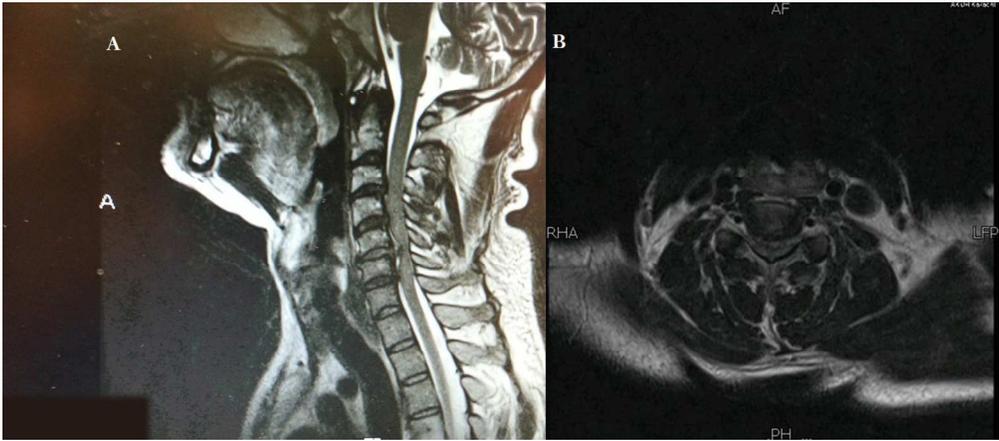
(a-b). MRI cervical spine pre procedure, in sagittal plane T 2 sequence (1a) and axial T 2 sequence (1b), demonstrating annular tear and acute disc prolapse at C 5/6 level with subtle hyperintense signal changes in the spinal cord representing edema and cord compression.
